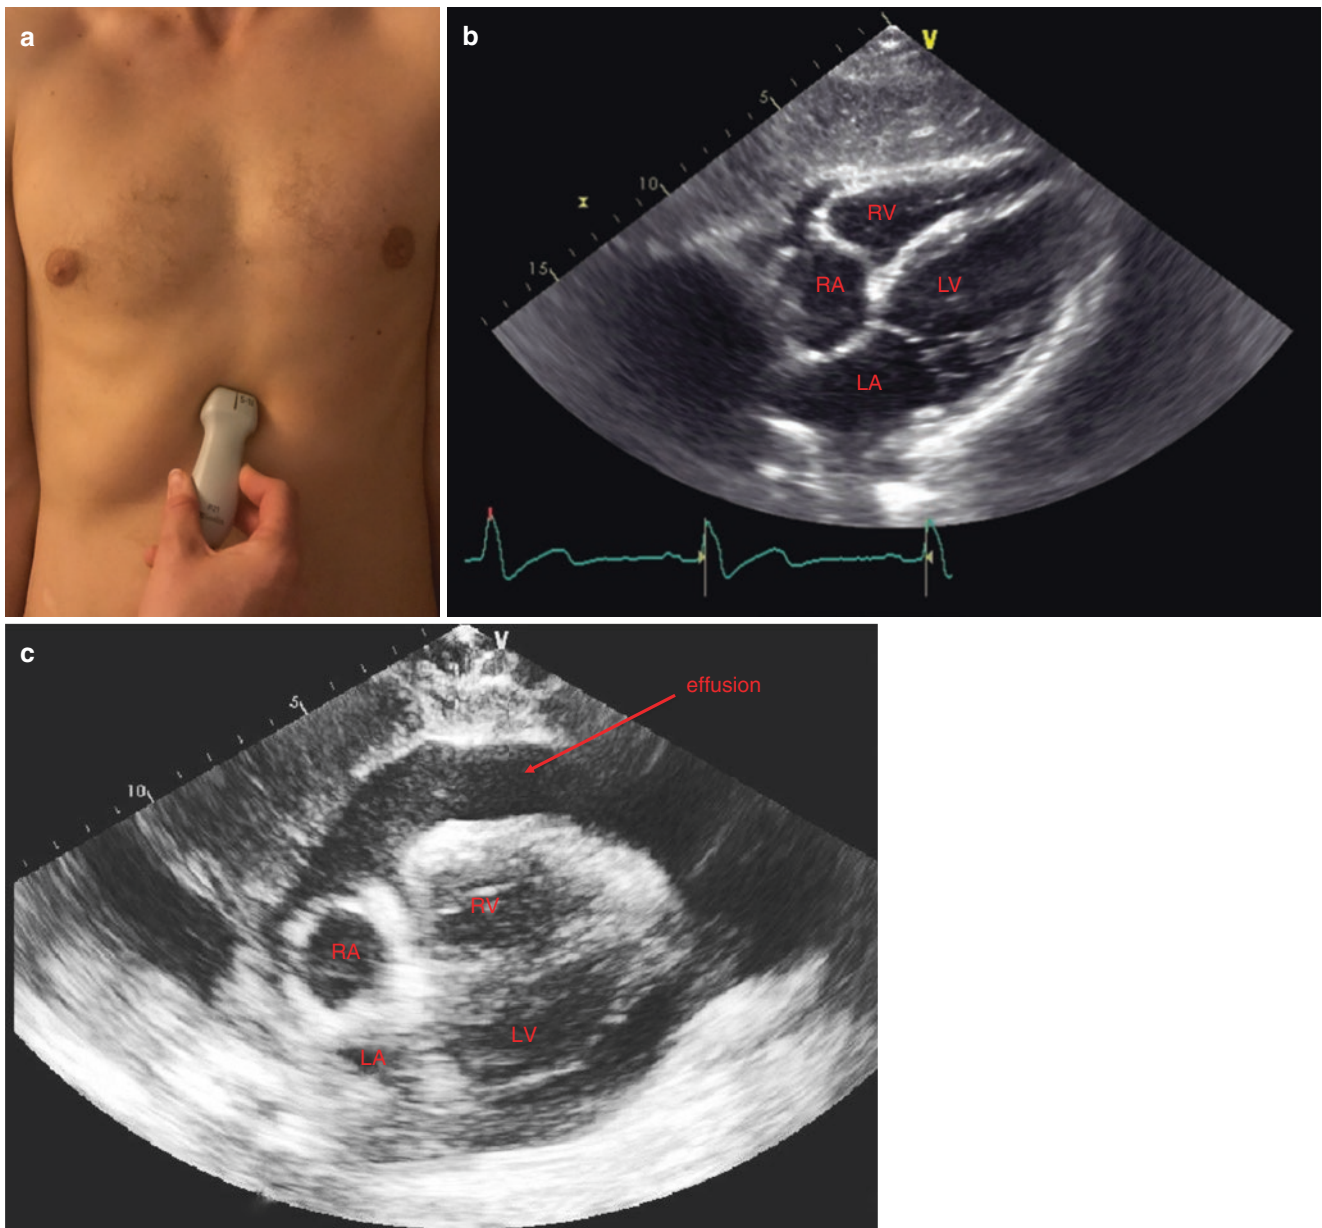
(a) Subxiphoid probe position. (b) Normal ultrasound image subxiphoid view. (c) Subxiphoid view with pericardial effusion
